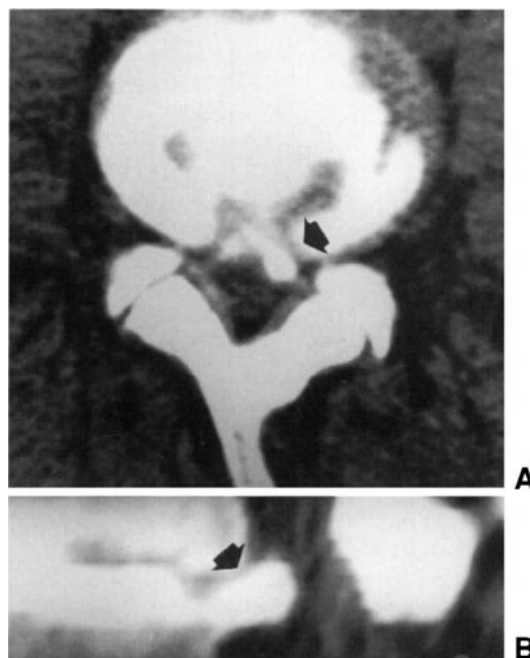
Disco-CT. (A) Axial scan. (B) Sagittal reconstruction. Subligamentous extruded herniation: the contrast medium opacifies the herniated tissue (arrows).
